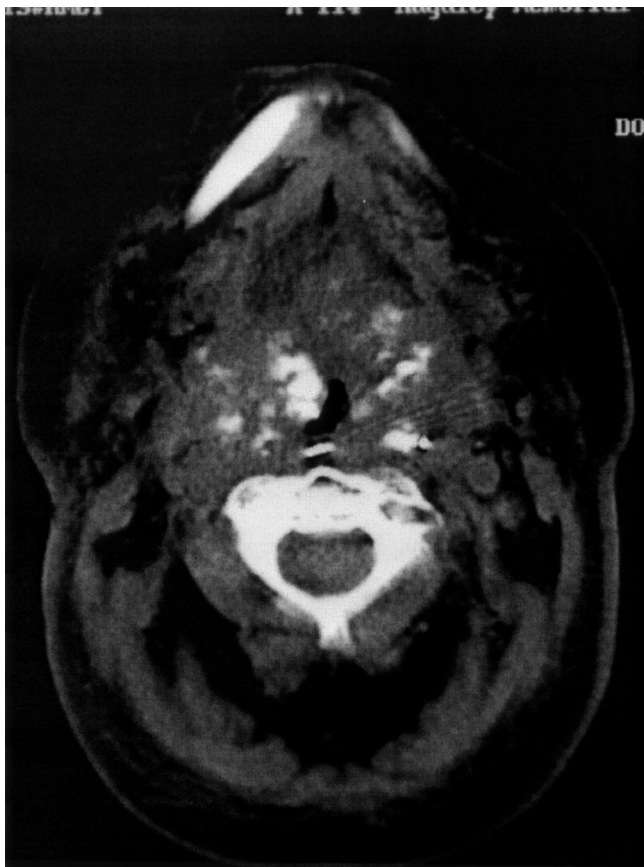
Axial computed tomography scan demonstrating dystrophic calcification associated with a soft tissue mass of the endolarynx.
